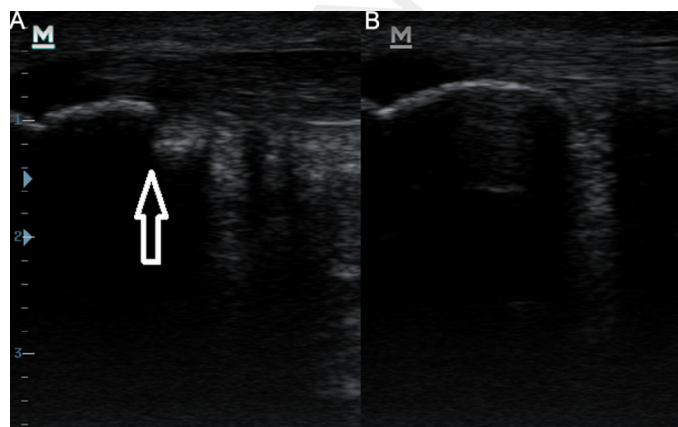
Ultrasonography of the (A) affected and (B) unaffected insertion of the Achilles tendon on calcaneus.
